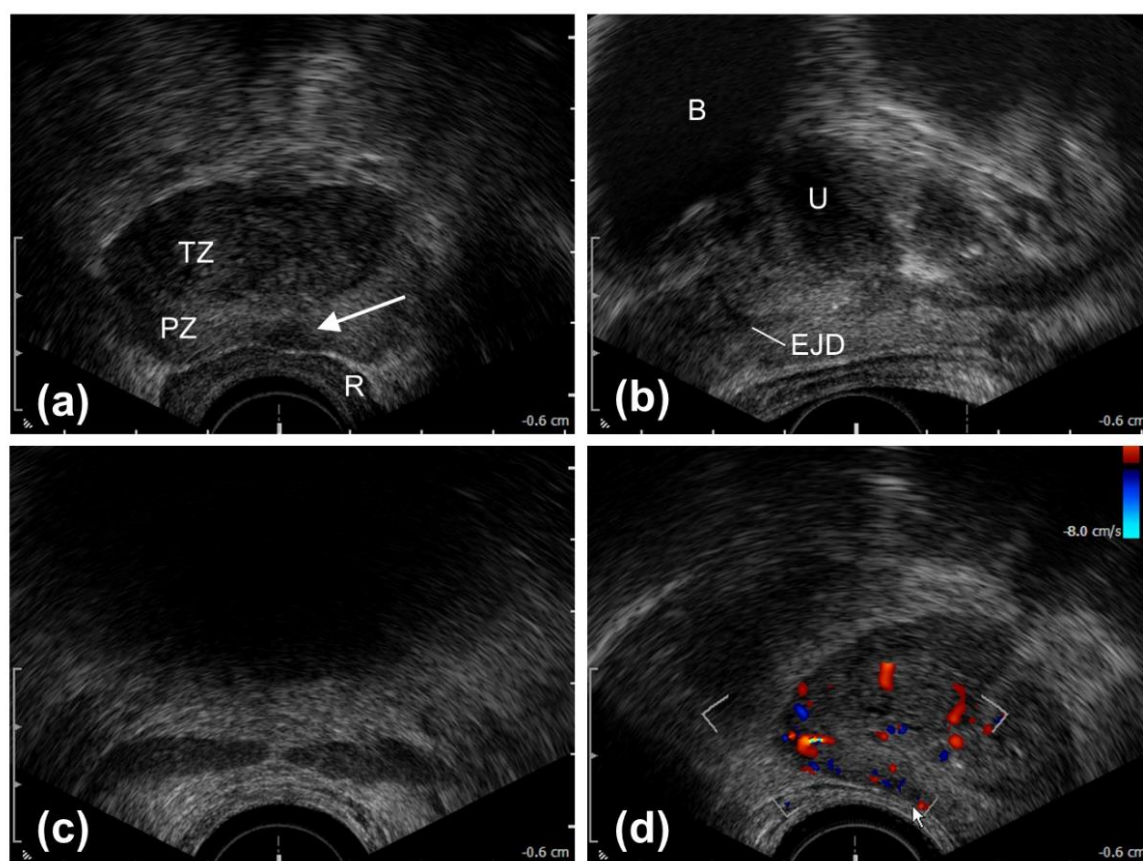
A “survey” scan of the prostate. (a) Transverse view. TZ, transitional zone; PZ, peripheral zone; R, rectal wall; hypoechoic lesion (*white arrow*). (b) Sagittal view. B, bladder; U, urethra; EJD, ejaculatory ducts. (c) Seminal vesicles. (d) Color Doppler imaging.
